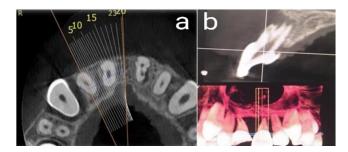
a: Axial view of CBCT scan showing the two-rooted maxillary left central incisor with thinning of the dentinal walls due to external root resorption. b: CBCT sagittal view of tooth #21 showing two distinct roots, with an apical third lesion and resorption localized in the coronal third of the tooth.
